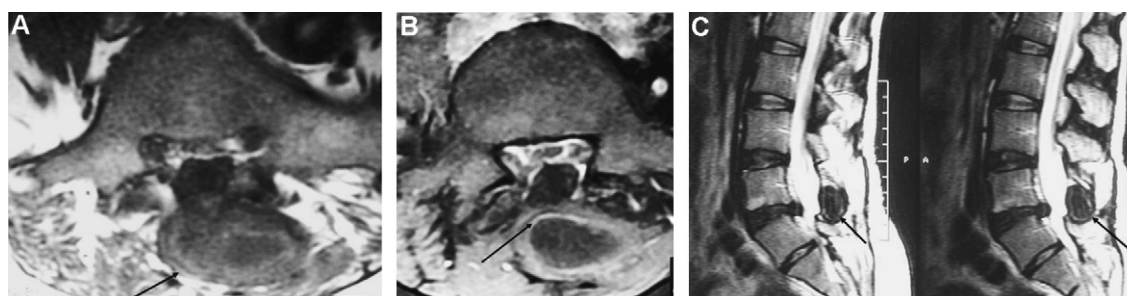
Axial T1-weighted magnetic resonance imaging (MRI) without (A) and with (B) contrast enhancement showing a ring-shaped, hypointense ellipsoidal lesion with a hypointense center in the right paravertebral soft tissue (arrow). A sagittal T2-weighted MRI (C) shows a posterior paravertebral mass with low signal intensity at the level of L4–L5 (arrow).
